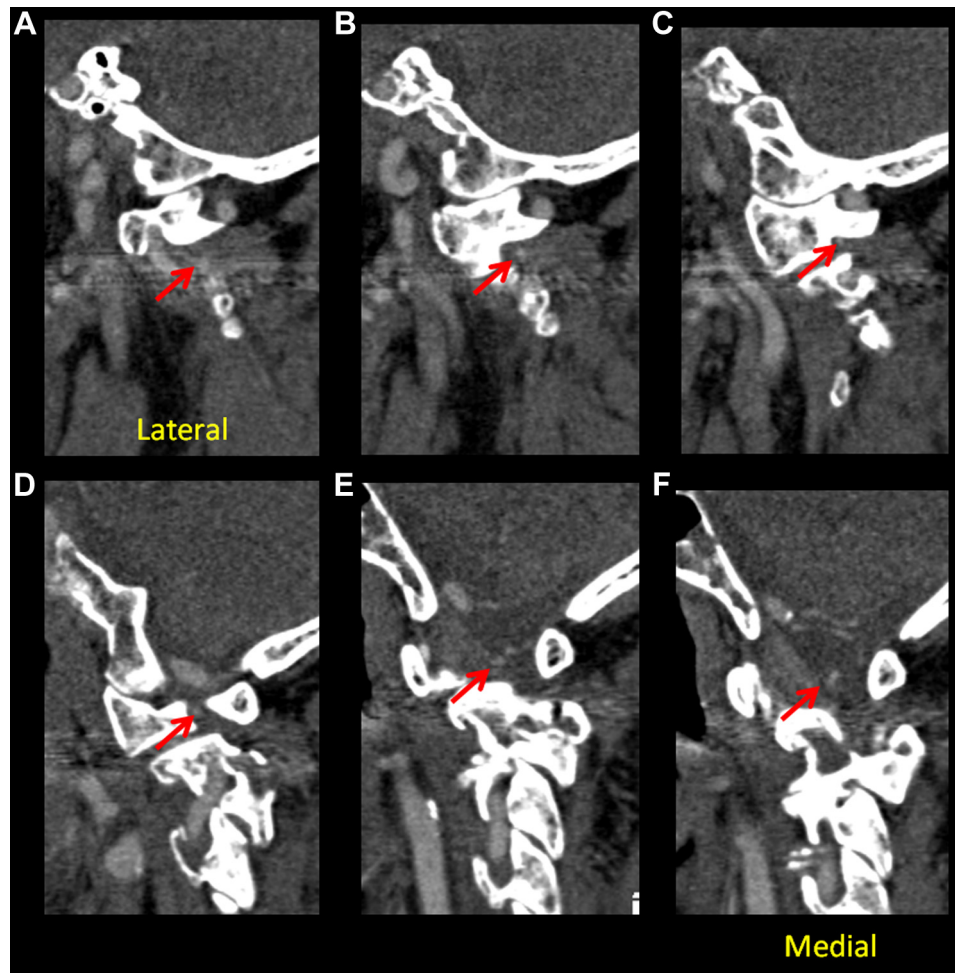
(A-F demonstrating cuts from Lateral to Medial) Computed tomography angiography sagittal reconstructions demonstrating the relationship of the aberrant posterior inferior cerebellar artery and its relationship to the C1 lateral mass screw entry point. Red arrow follows the course of the PICA.
